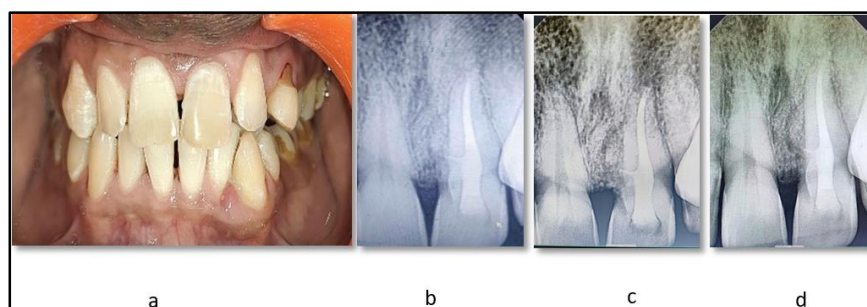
Postoperative a) intra-oral picture; b) Follow up radiograph- 3 months; c) 6 months; d) one-year
